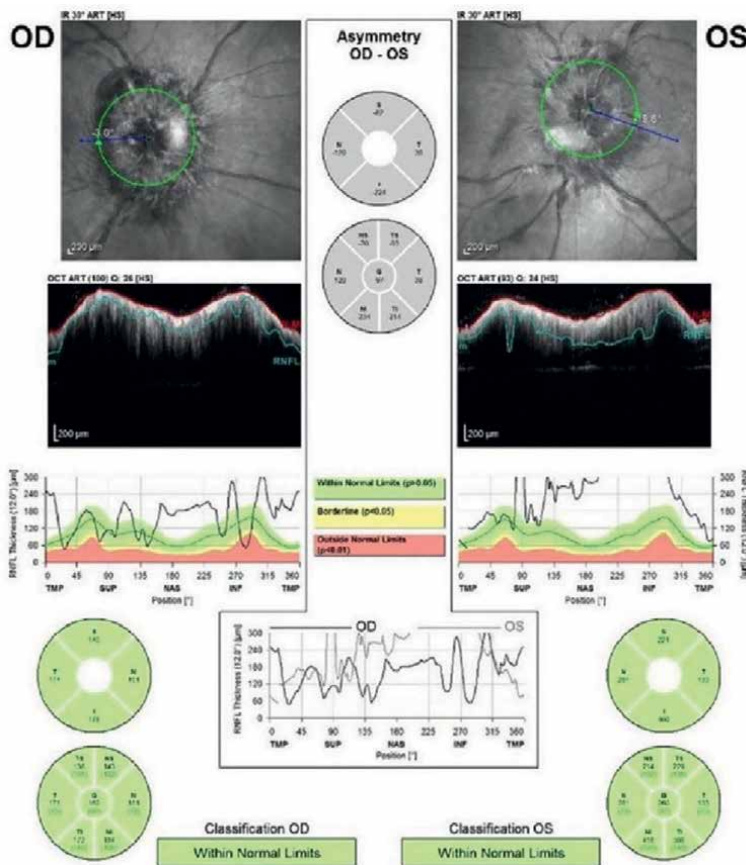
Infiltrative optic neuropathy: A, peripapillary OCT of both eye. The right eye, increased thickness of RNFL in all four quadrants. The left eye, normal RNFL thicknesses in all sectors. B, B-scan ultrasonography of the right eye reveals abnormally increased optic nerve sheath diameter (red double-headed arrows). C, in FA a hyperfluorescent mass on the right optic disc with no evidence of leakage is visible.
